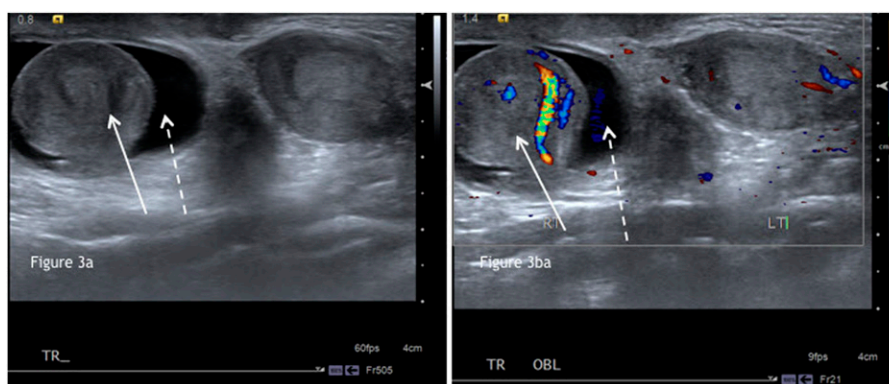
These images demonstrate the bilateral testes in the transverse plane. Again, there is a heterogeneous, coarse echotexture of testis bilaterally. The Doppler image shows flow present within both testicles.
